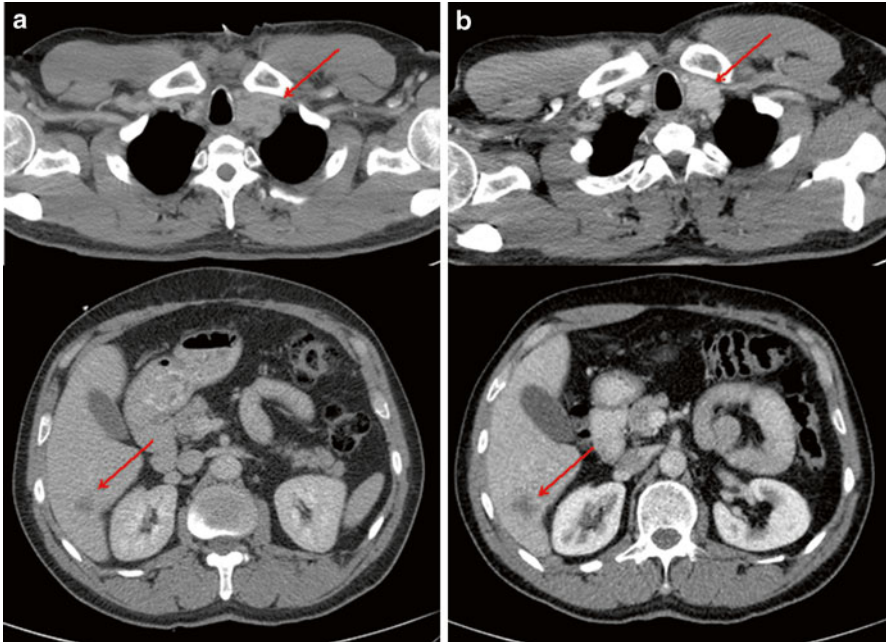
Radiographic assessment conducted in February 2012 (a) and September 2012 (b) during treatment with vandetanib. Stable disease was achieved on the *left* supraclavicular lymph node (arrow) and the *right* liver lobe lesion (segment VI) according to RECIST criteria v1.1
